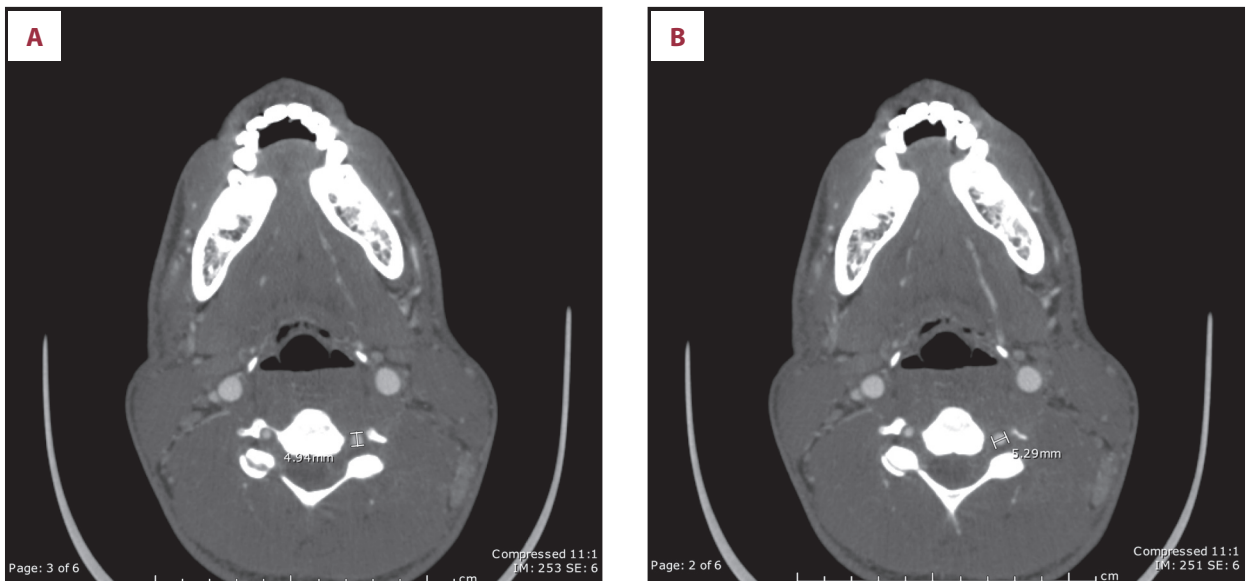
(A, B) CT angio head/neck: There is focal aneurysmal dilatation of the left vertebral artery at the C₄ level; this may be secondary to infectious changes. No definite dissection is seen at this level.
